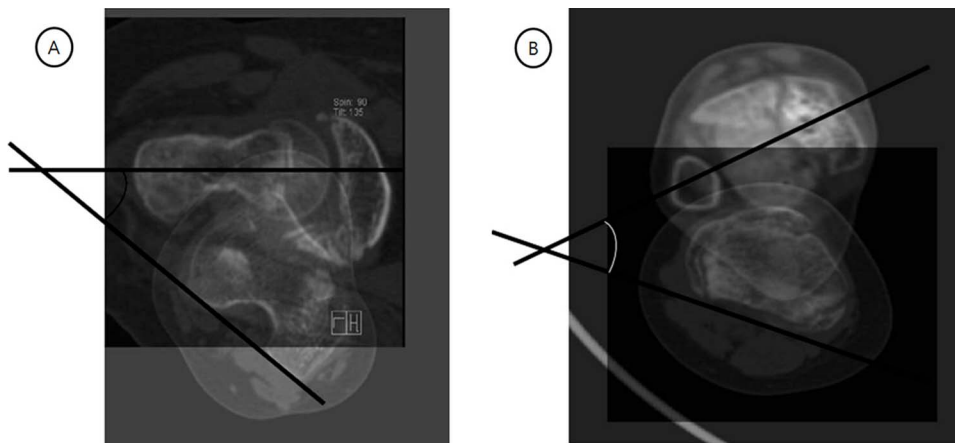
Measurement of FAV (femoral anteversion) and TT (Tibial torsion) on the CT images.
